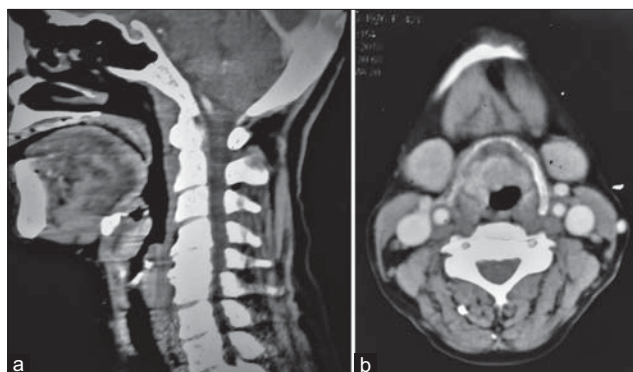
Contrast-enhanced computed tomography showing diffuse asymmetrical thickening with homogeneous enhancement in the epiglottis and aryepiglottic folds (a) sagittal view, (b) axial view
